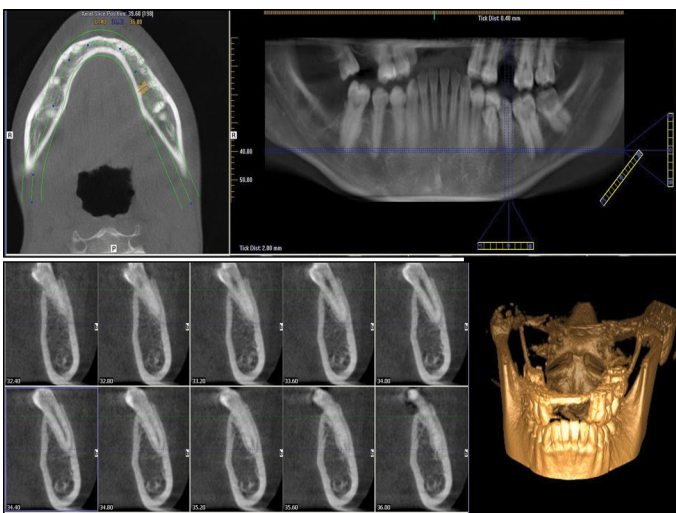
CBCT of second parapremolar.
